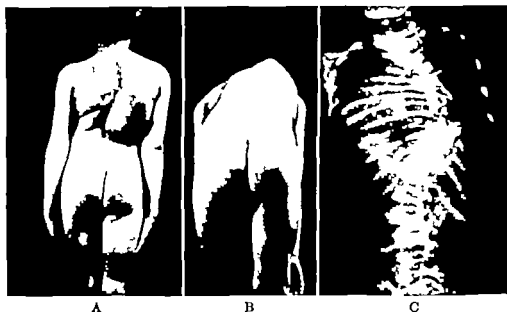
Long right dorsal short left lumbar scoliosis. A Patient in upright position. B Patient in forward bent position. C Roentgenogram of spine.
